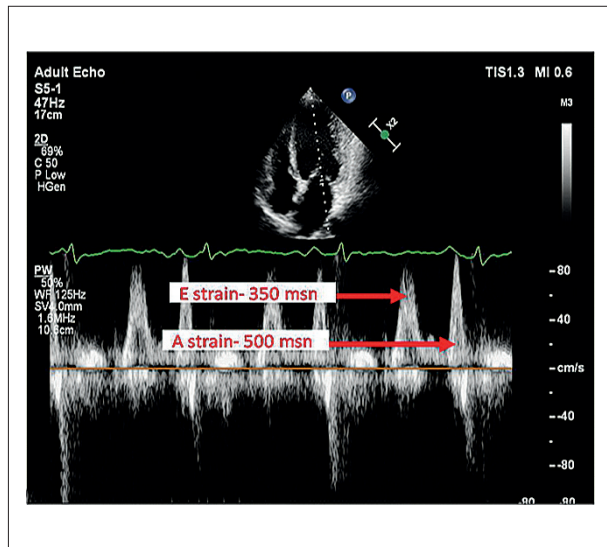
The relationship between strain velocity with the electrical activity of the heart on echocardiography. Electrical measurement times were taken from the peak point of the QRS wave to the peak points of the E wave and A wave on horizontal ground.
